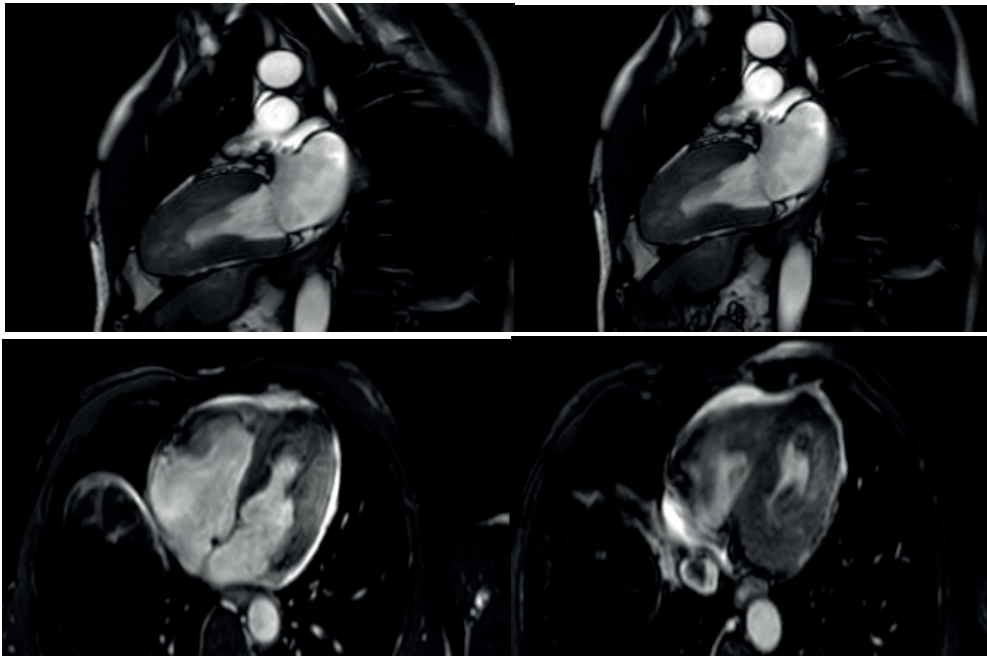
MRI with the presence of the double V sign in the myocardium
